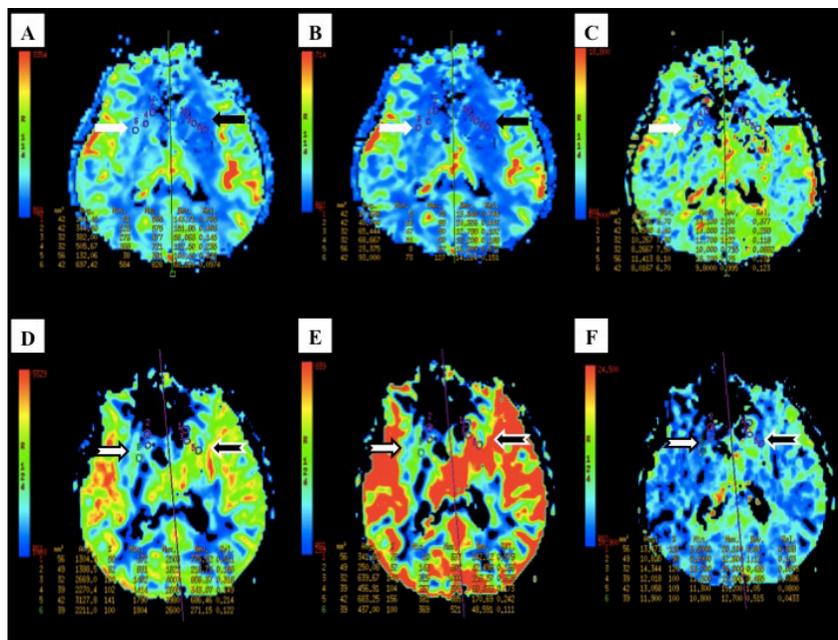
The top row representing the MRI perfusion maps pre-treatment in rCBF (A), rCBV(B) and MTT (C) and the bottom row representing the MRI perfusion maps post-treatment in rCBF (D), rCBV (E) and MTT (F), showed generalised increased in rCBF and rCBV particularly comparing the infarcted regions pre-treatment (black arrows) and infarcted regions post-treatment (notched black arrows). The MTT maps post-treatment (F) generally showed reduced MTT compared to the MTT pre-treatment (C), however not statistically significant. The blue color (bottom of colour scale) indicate lowest perfusion value and the red color (top of colour scale) indicate highest perfusion value.
